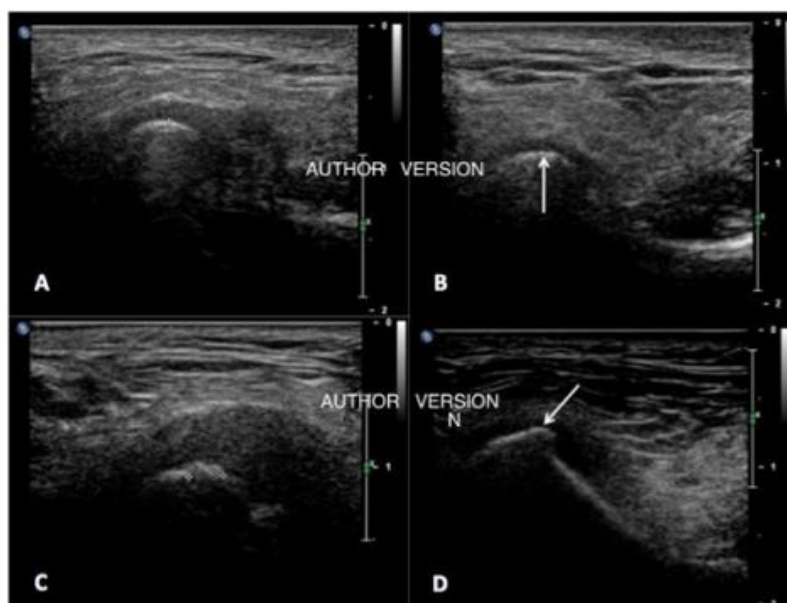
Different stages of condylar head articular surface degeneration visible on ultrasound pictures. Normal smooth surface of the condylar head (A). Subchondral sclerotic changes-typical for overload (arrow) (B). Cartilage destruction with penetration of productive changes (marked by clippers) (C). Osteophyte formation (arrow) (D)
